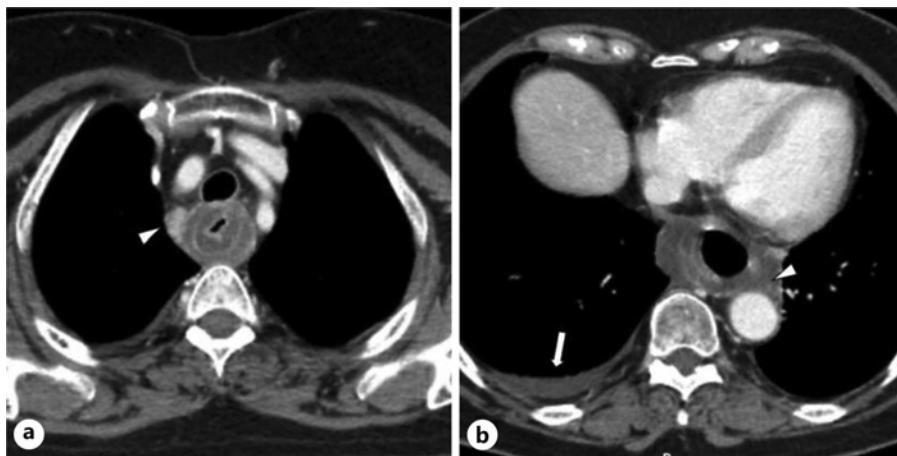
Axial planes from same CT scan at upper thoracic esophagus level (a) and lower thoracic esophagus level (b) show miliary involvement of the esophageal serosa with diffuse and regular thickening of all layers of the wall of the thoracic and abdominal esophagus. It is associated with enlarged mediastinal lymph nodes (a, arrowhead), a slight amount of periesophageal fluid (b, arrowhead), and a right pleural effusion (b, arrow).
